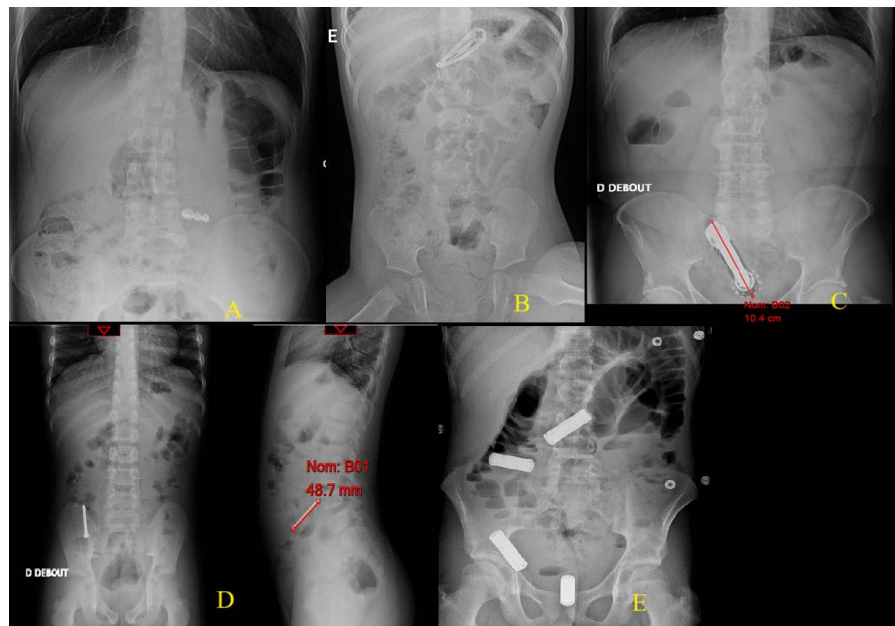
Abdominal radiography plain (A: Bridge dental, B: Hair clip, C: Vibrator, D: Nail, E: Batteries).
